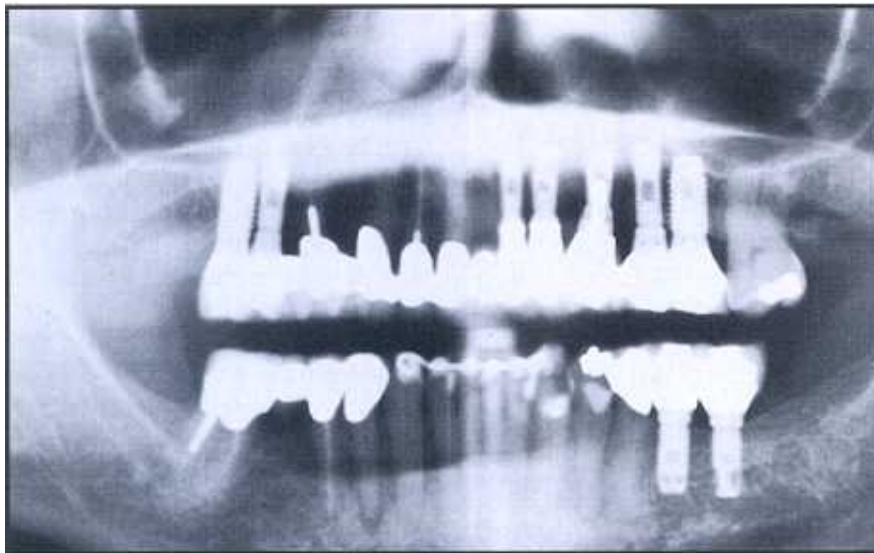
Postrestorative panoramic radiograph.
